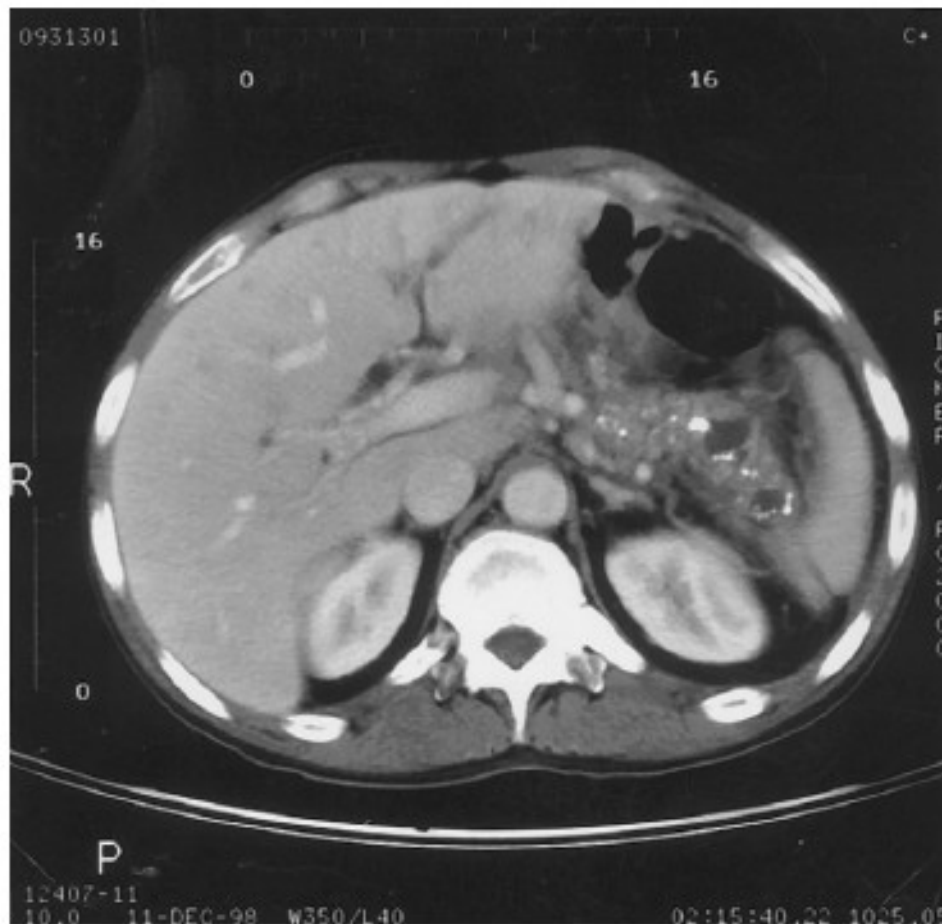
Computed tomography scan of a patient with calcifications and small pseudocysts in the pancreas consistent with chronic pancreatitis.
